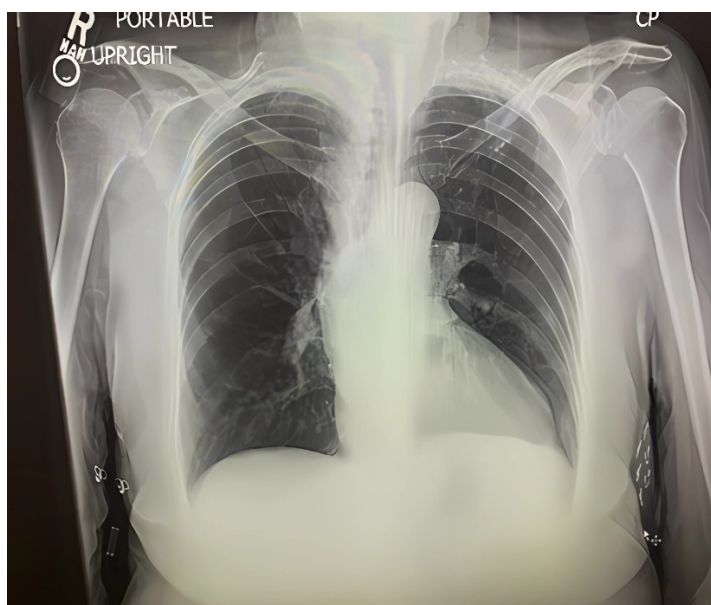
Frontal chest radiograph showing clear lung fields without infiltrates or signs of pulmonary congestion. A moderate left pleural effusion is noted, evidenced by blunting of the left costophrenic angle; cardiac silhouette is normal in size.
